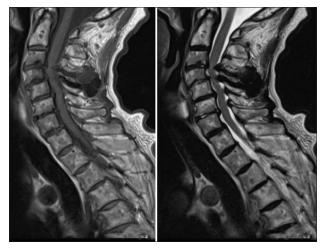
MRI performed prior to the operation showing a large low-intensity mass on both TI- and T2-WI, suggesting the mass to be calcified
